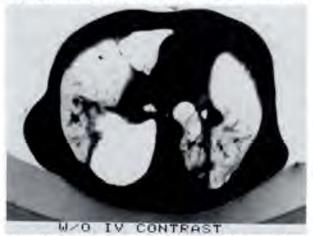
Computed tomogram of chest in 1990, showing large apical bullae and fibrotic scarring of remaining lung with nodular infiltrate.
